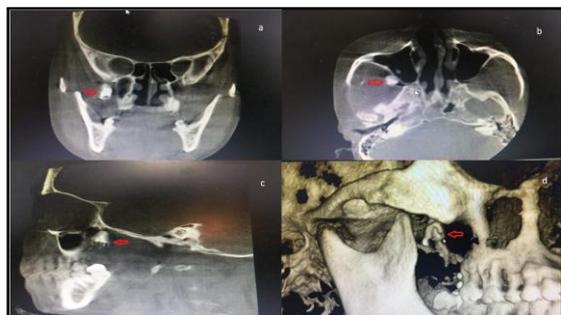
Cone beam computed tomography scan (CBCT) was carried out which suggestive of dislodged third molar into right infratemporal region.
